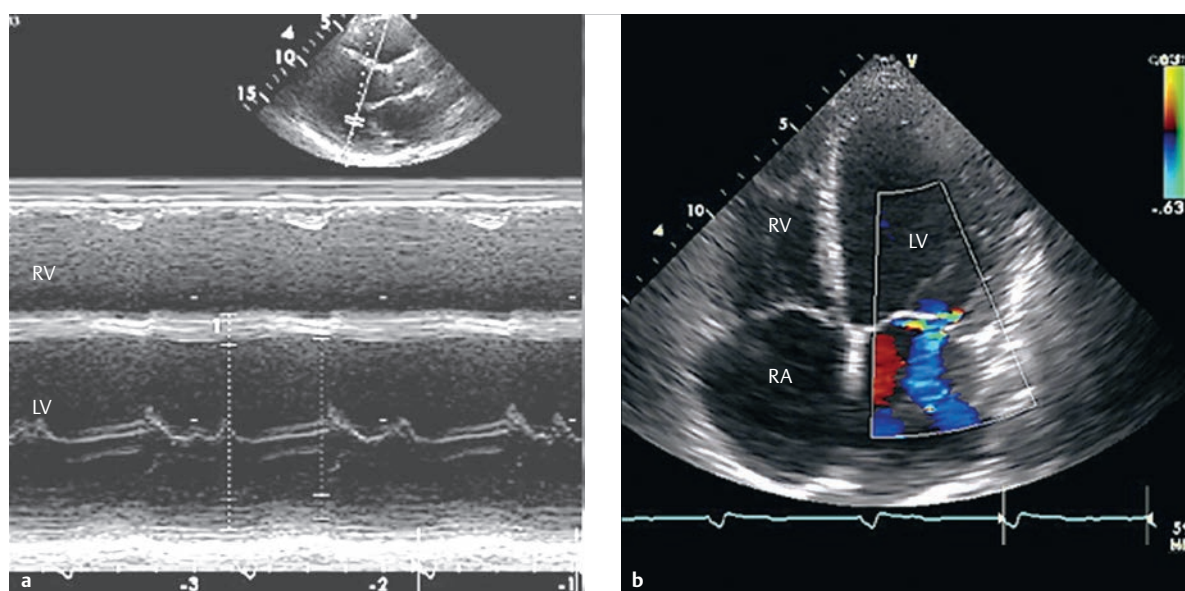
DCM. 2-D transthoracic echocardiography in a 16-year-old boy with severe DCM (end diastolic diameter of 84 mm, end systolic diameter of 74 mm, fractional shortening of 12%) on the day before a left ventricular assist device was placed.
